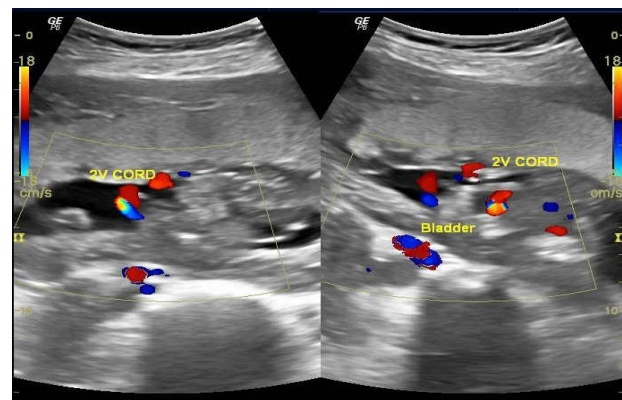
Ultrasound image showing two vessel umbilical cord (with absence of one umbilical artery)
